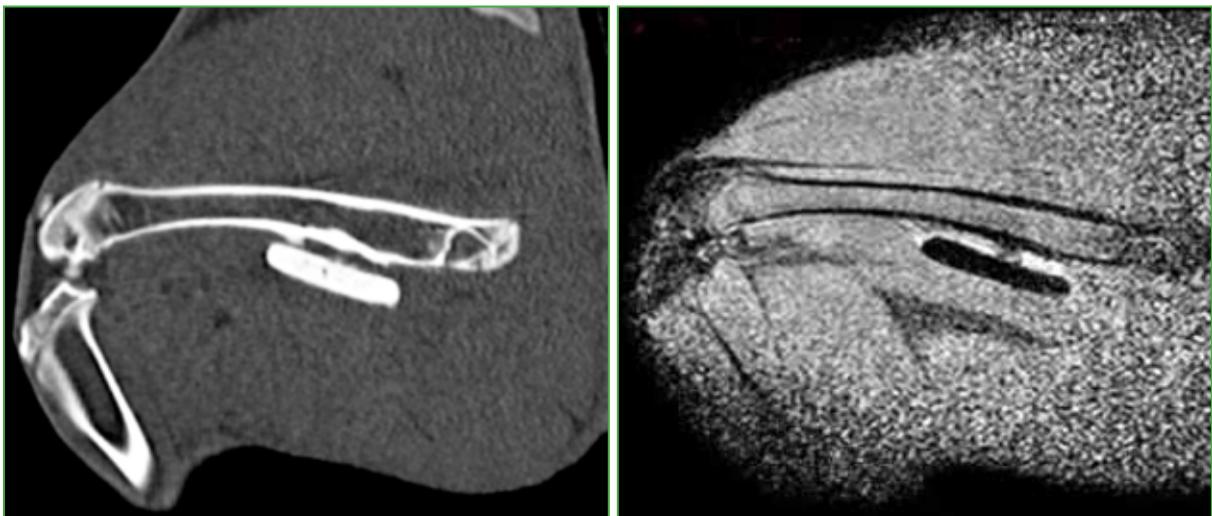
MRI. Antibiotic-coated cement spacer.
